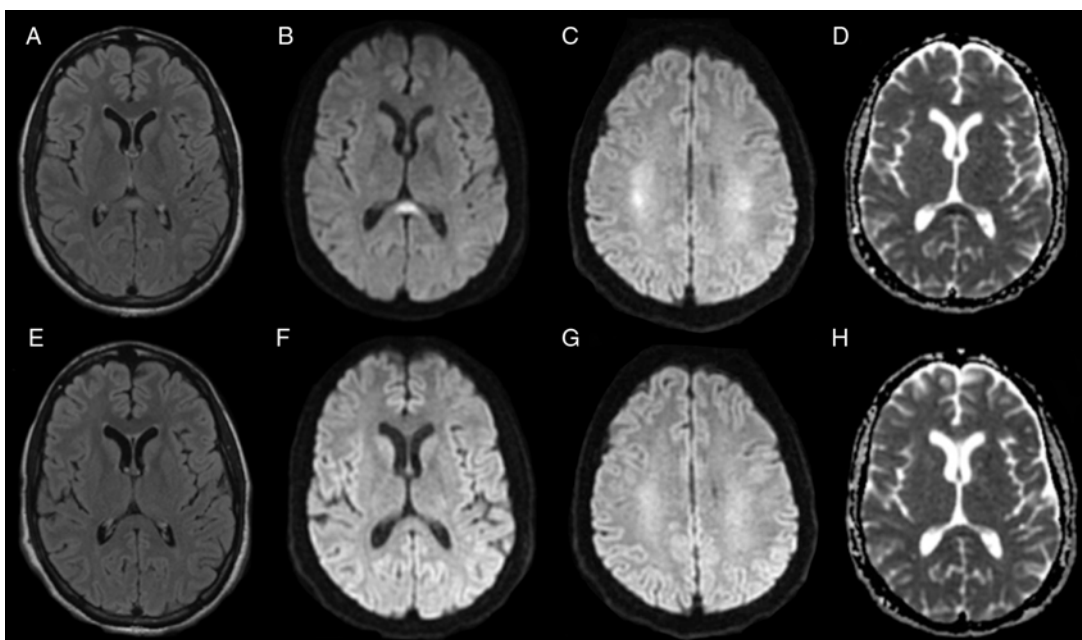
Axial MRI sequences from day 1 (A–D) and day 7 (E–H) following presentation. (A) T2 fluid attenuation inversion recovery (FLAIR) sequence shows hyperintensity of the splenium of the corpus callosum. (B) Diffusion-weighted imaging (DWI) sequence shows hyperintensity of the splenium, and (C) bilateral centrum semiovale. (D) Corresponding low apparent diffusion coefficient values. (E–H) corresponding T2 FLAIR, DWI, and apparent diffusion coefficient sequences on day 7 following presentation which show resolution of diffusion restriction in the splenium and centrum semiovale.
